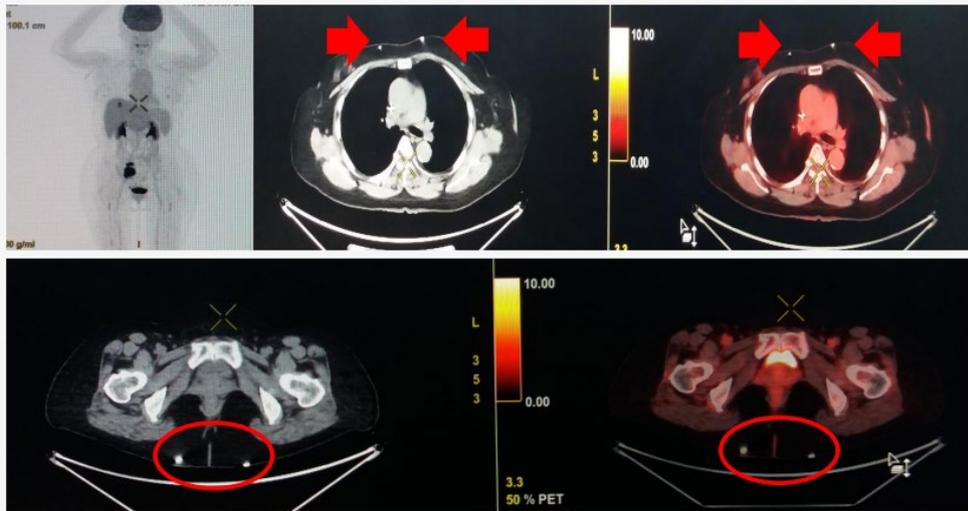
FDG avid liver and right pelvic lesions. Susuk needles causing local metal artifact including at the anterior chest wall (arrows) and gluteal regions bilaterally (circles).
